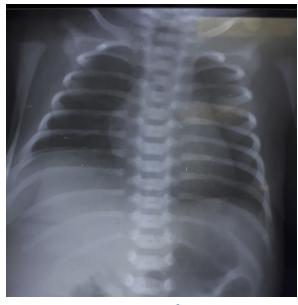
Chest X-ray showing slightly involvement in right pulmonary with cardiac size after surfactant therapy
